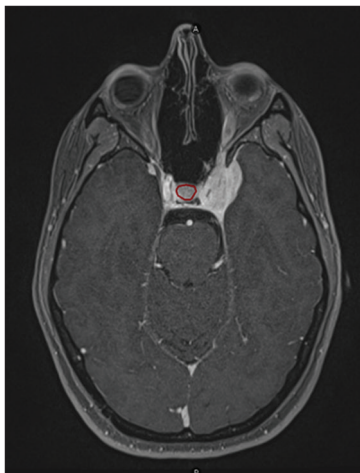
Post-treatment magnetic resonance imaging (MRI). Colour only provides a visual representation of the cited area (residual mass).
